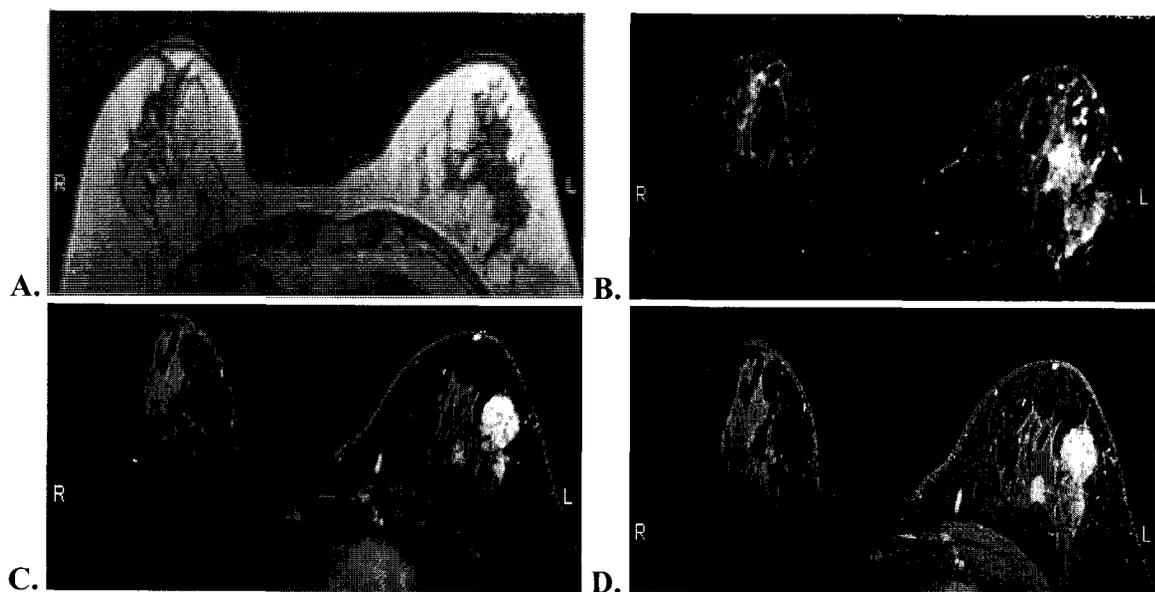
Patient 3 images from each scan performed. A) is slice 34 from the T1-weighted scan. B) is slice 34 from the T2 SPAIR scan. C) is slice 317 from the Dynamic Thrive scan. D) is slice 77 from the Thrive Post scan.
